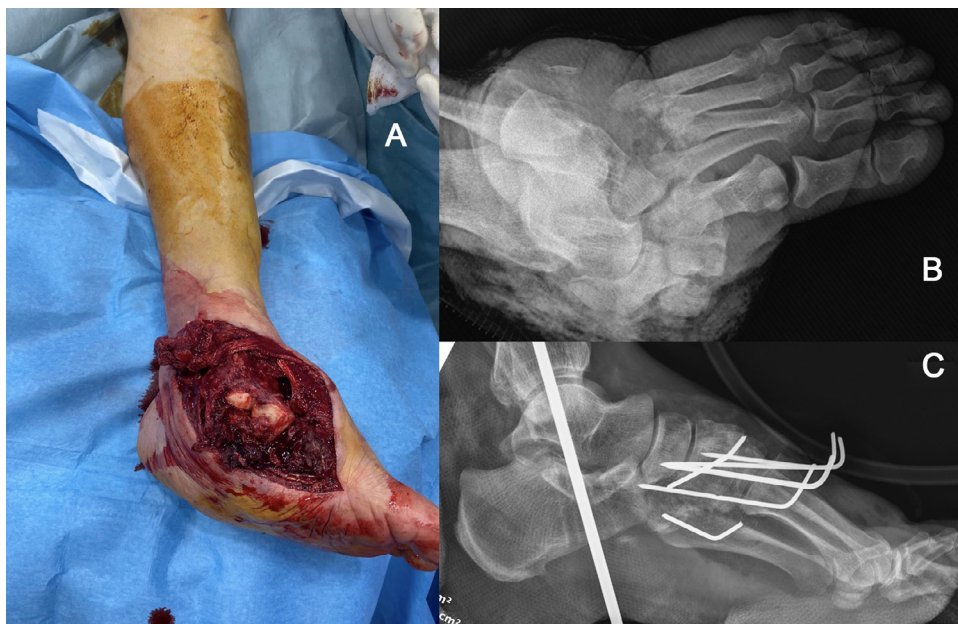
(A) Mixed region injury accompanying Type IIIb open fracture. (B) Anterior posterior foot X-ray showing mid- and hindfoot injury and multiple dislocations. (C) Postoperative lateral foot X-ray of a patient applied with open reduction and percutaneous pinning.
